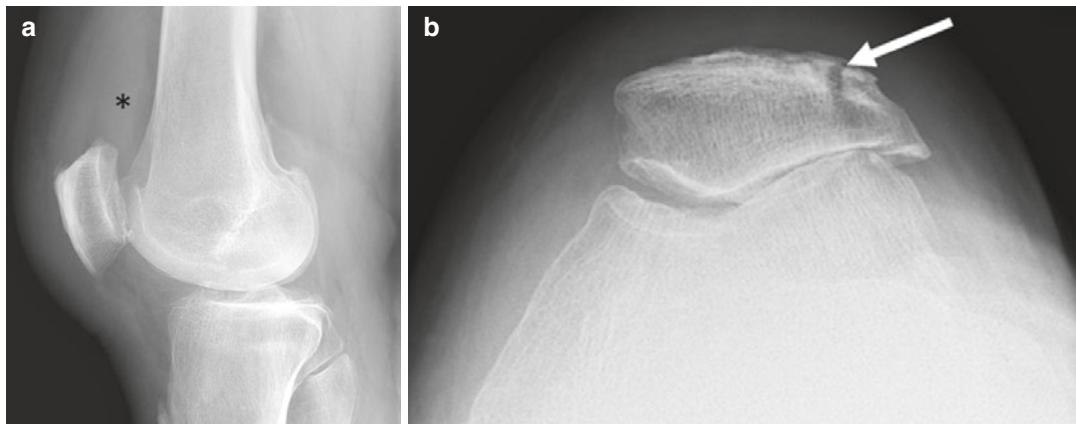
Sixty-two-year-old man with patellar fracture. Lateral (a) and AP (not shown) knee radiographs showed anterior soft-tissue swelling and a joint effusion (asterisk).
